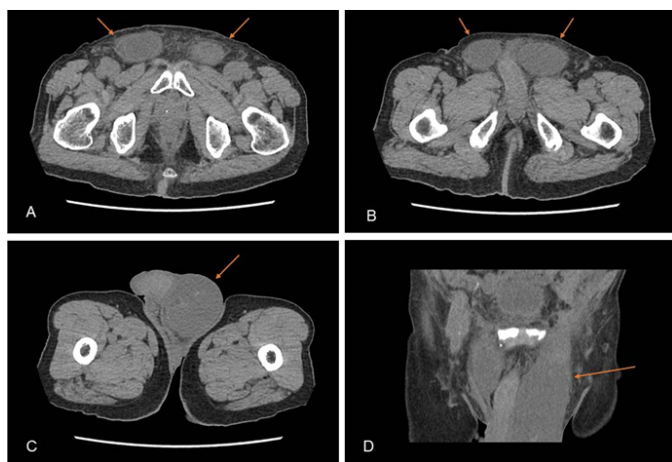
CT scan images (A-C axial view, D coronal view) showing a 13x5x6 cm collection extending from the superomedial aspect of the inguinal region into the left hemi-scrotum and a 7x3x4 cm collection on the right inguinal area (arrows indicate the collection).
